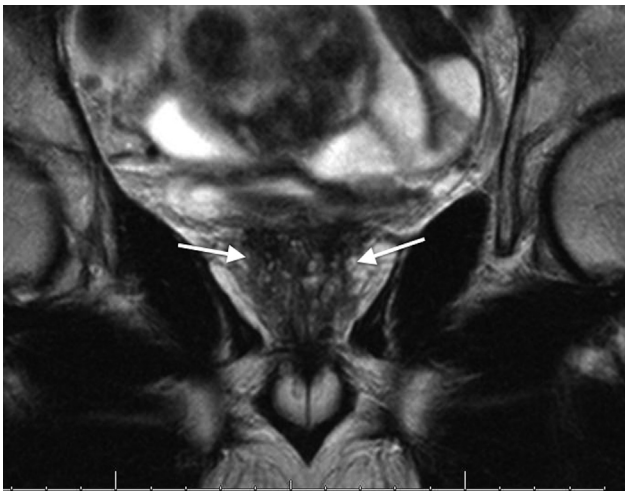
Coronal T2-weighted MR image demonstrates nodular central gland with low signal intensity (arrows) in a 62-year-old patient with small-volume BPH (27.6 cm³) who was taking finasteride, silodosin, and tamsulosin, with a baseline AUA (QOL) score of 33 (6) and IIEF of 15.
